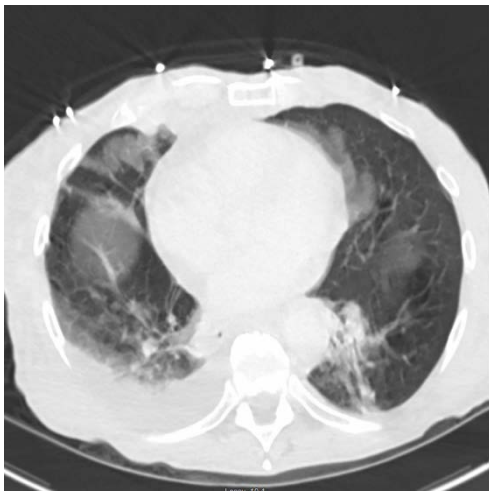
CT chest imaging showing widespread metastatic disease
